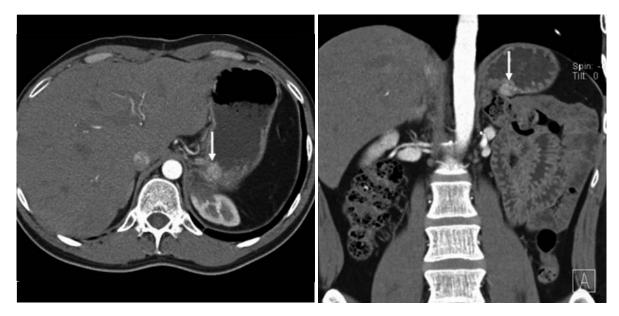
Enhanced visualization of GI pathology at CT enterography. Axial (*left*) and coronal reformatted image (*right*) shows enhancing hyper vascular neuroendocrine tumor (*arrows*) in stomach
